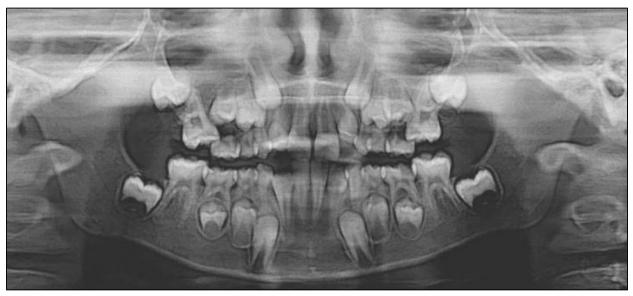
Preoperative orthopantomogram showing ectopically erupted permanent maxillary first molars (case 1).
